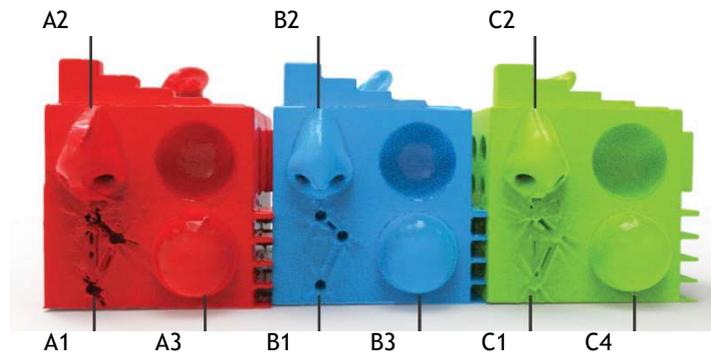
CT Results of Anchor point (3D Doctor® A1, B1, C1), Anatomical (Mimics® A2, B2, C2) and Spherical (Invesalius® A3, B3, C3) Test Features.
